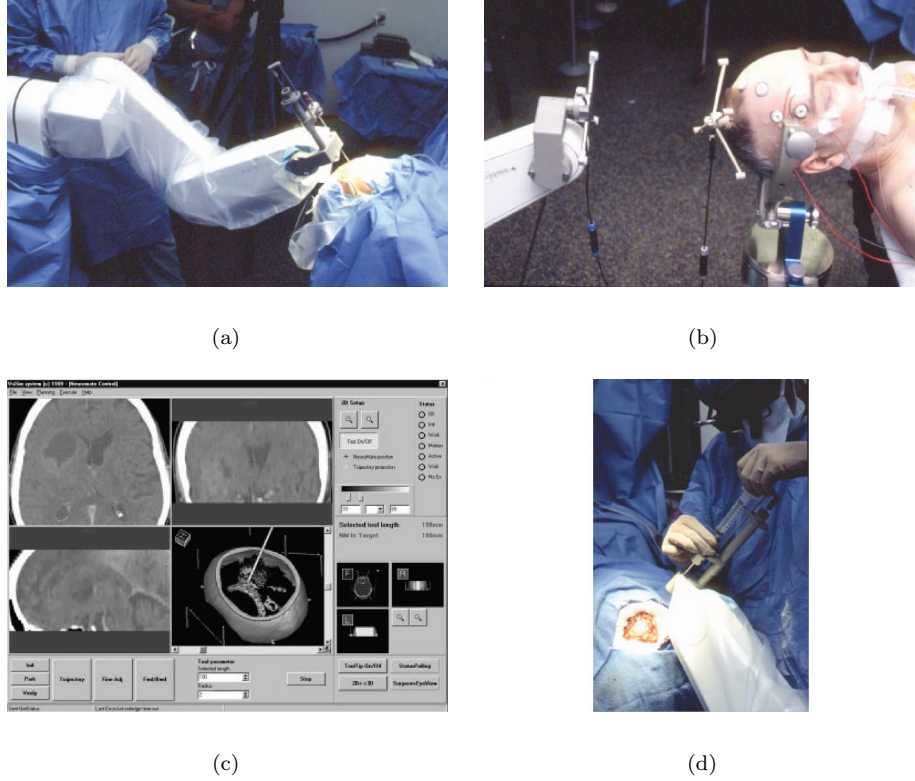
Robotic brain surgery. (a) The robotic arm holding an aspiration needle. (b) Robot-to-patient registration with optically tracked fiducials. (c) Screenshot from CT-based treatment planning. (d) Surgeon performing the aspiration. (After [36])
